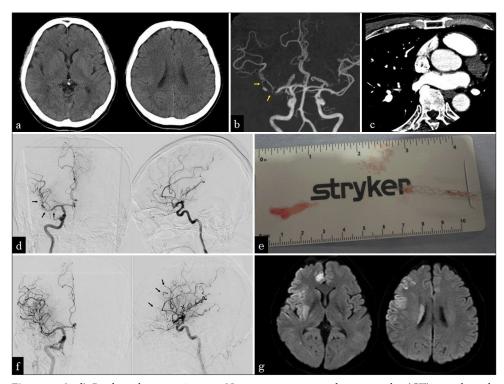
(a-d) Prethrombectomy images. Noncontrast computed tomography (CT) reveals early ischemic changes in the right frontal operculum, temporal operculum, and insular cortex (a). Threedimensional CT angiography shows contrast defects at two sites: the right distal M1 segment and the distal M2 segment of the lower trunk, indicated by arrows in (b). Contrast-enhanced CT of the chest reveals no clearly visualized intracardiac thrombi or cardiac tumors (c). Cerebral angiography (left: anteroposterior view; right: lateral view) shows poor contrast at several sites: The distal M1 and the distal M2 segments of the lower trunk of the right middle cerebral artery (MCA), and the right anterior temporal artery, indicated by arrows in (d). (e) Two emboli were retrieved with a stent retriever, corresponding to the contrast defects of MCA. One of them has broken away from the tip of the stent retriever. They appear white and gelatinous. (f and g) Postthrombectomy images. Cerebral angiography (left: anteroposterior view; right: lateral view) shows distal embolization in the frontopolar artery, the posterior parietal artery, and angular artery (indicated by arrows), with reperfusion achieving thrombolysis in cerebral infarction grade 2b (f). Diffusion-weighted magnetic resonance imaging shows high-signal intensity areas in the right frontal operculum, temporal operculum, insular cortex, medial frontal gyrus, cingulate gyrus, putamen, and corona radiata (g).
